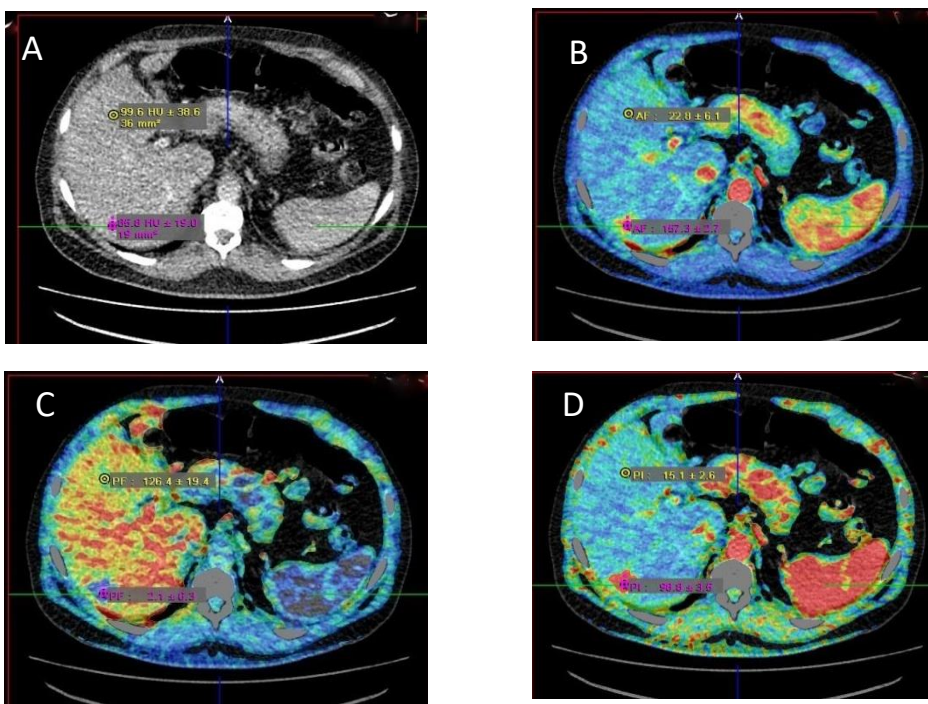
CT perfusion of the right hepatic lobe focal lesion shows: (A) CT attenuation value of the focal lesion in first pass perfusion of contrast displays nearly the same attenuation value of the normal hepatic parenchyma (focal lesion = 85.6 HU, normal parenchyma = 99.6 HU). (B) High arterial flow (AF) of the focal lesion (157.3 ml/min/100ml). (C) Low portal flow (PF) of the lesion (2.1 ml/min/100ml). (D) Perfusion index of the lesion higher than the normal liver (PI=98.8).
